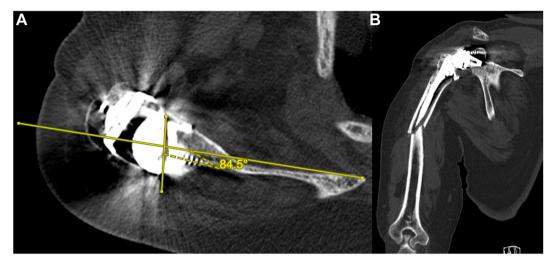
Computed Tomography confirming a well-positioned glenoid component and a periprosthetic fracture at the tip of the stem (Type IIA).
